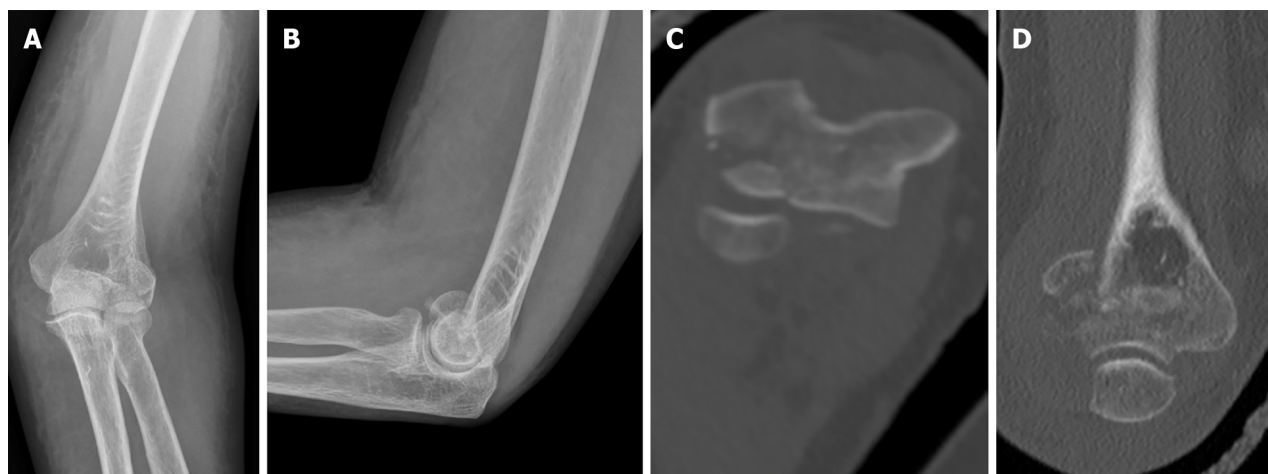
Injury films on presentation depicting a left Bryan and Morrey type 3 capitellar fracture. A-D: Anterior posterior (A) and lateral (B) radiographs, axial (C) and coronal (D) computer tomography cuts depicting the injury.
